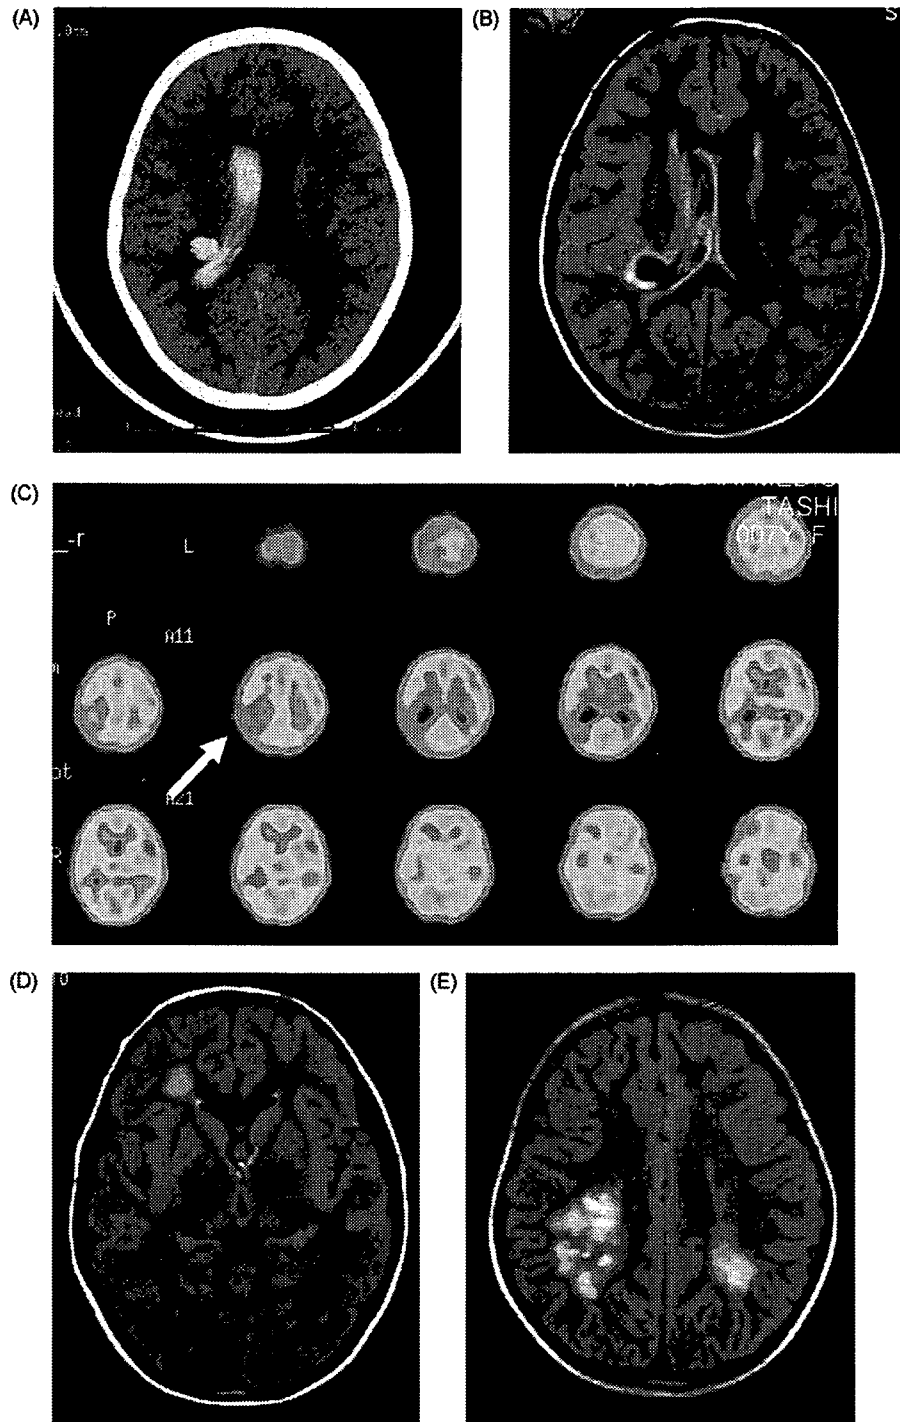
(A) A computed tomographic scan demonstrated an intracerebral hemorrhage in the right paraventricular white matter and intraventricular clots. (B) No cerebral infarction was evident on fluid attenuated inversion recovery (FLAIR) magnetic resonance image. (C) Single photon emission computed tomography (SPECT) using *N*-isopropyl-4 iodoamphetamine (^{123}I -IMP) showed a marked reduction in the regional cerebral blood flow in the right parietal cortex (arrow). (D and E) FLAIR magnetic resonance images revealed multiple infarcts in the right frontal and bilateral parietal subcortexes.
